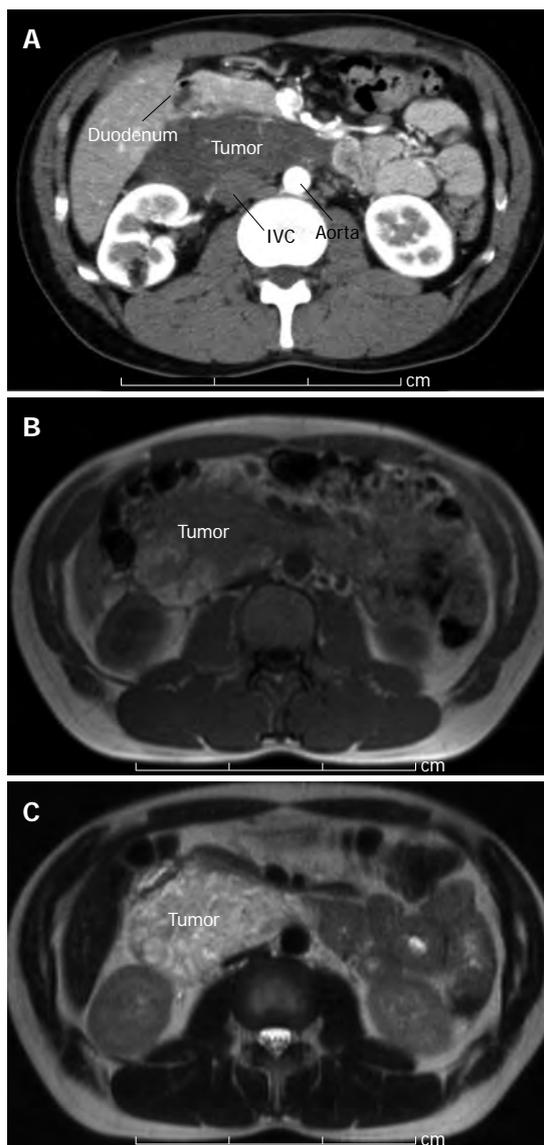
12 cm × 9 cm tumor was detected by computed tomography and magnetic resonance imaging. A: Abdominal enhanced computed tomography in early phase showed tumor without marked contrast. The tumor had pushed the pancreas to the ventral side; B: T1-weighted image of magnetic resonance imaging showed low and relatively high intensity area inside the tumor; C: T2-weighted image showed high intensity area with a few part of intermediate signal intensity area. IVC: Inferior vena cava.
